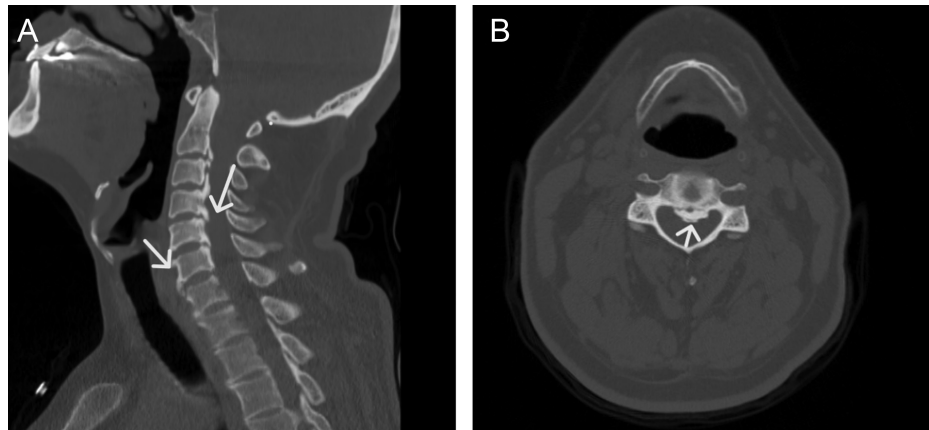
(A) In sagittal section of the Computed tomography, flowing ossification along the anterior and posterior aspects of 4 contiguous vertebrae was shown. (B) Also, in the axial section, mild narrowing of spinal canal is shown.
